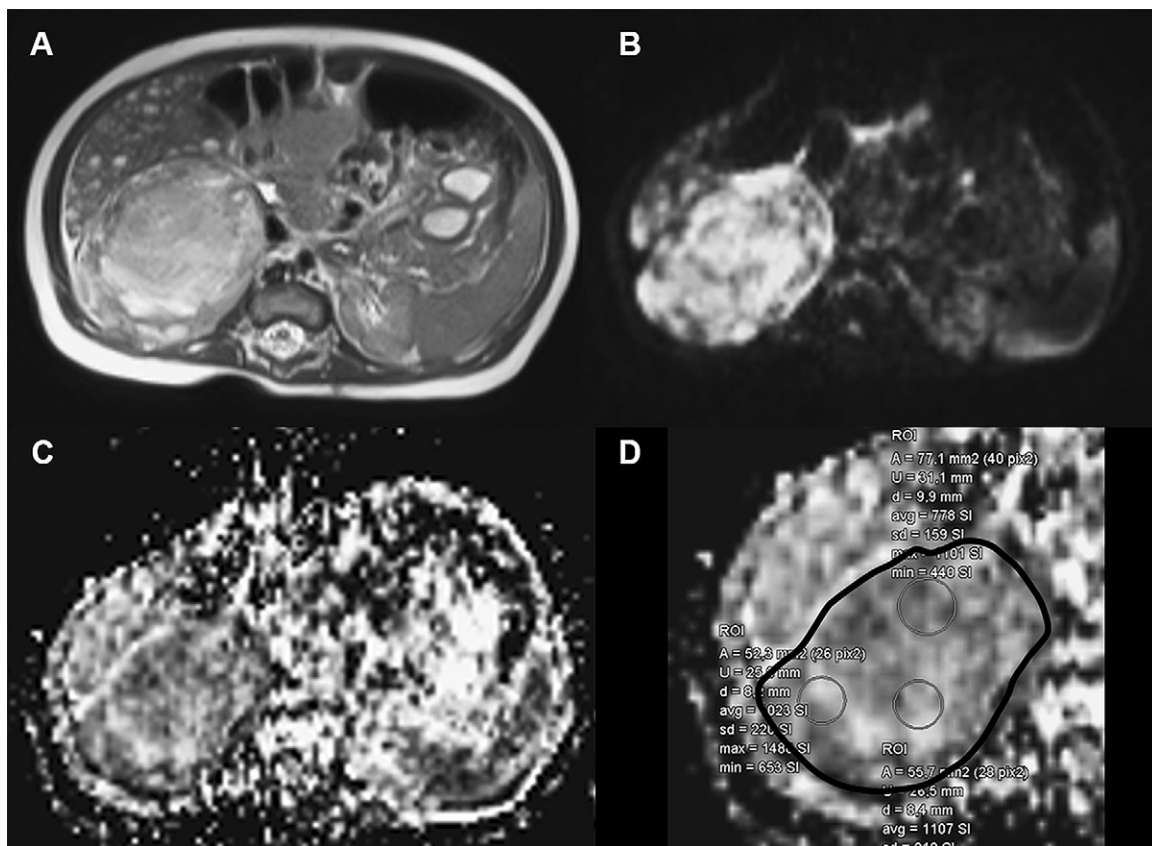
Images of a nonrelapsing neuroblastoma lesion in a 5-week-old male infant. The images include (A) a baseline axial T2-weighted image, (B) an axial diffusion-weighted image with b value of $800\text{sec}/\text{mm}^2$, and (C) an axial apparent diffusion coefficient map. The baseline apparent diffusion coefficient from the large region of interest was $0.883 \times 10^{-3}\text{mm}^2/\text{sec}$. (D) Locally enlarged image of (C) shows the different delineated regions of interest (ROIs) for measuring apparent diffusion coefficient values. (Adapted, under a CC BY 4.0 license, from reference 5.)
